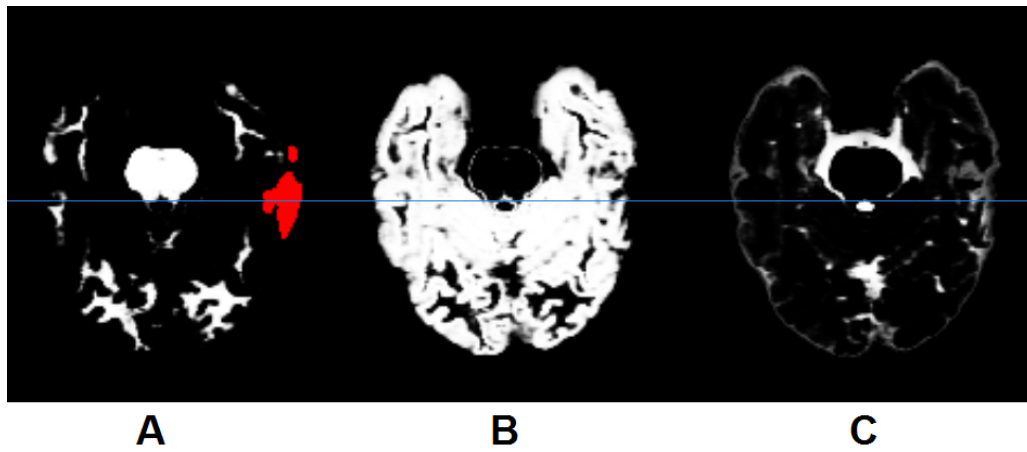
Most obvious slice of segmentations for patient P0836 MRI scan with emphasis on lesion area: grey matter TPM with manually delimited lesion area overlaid (A), white matter (B), CSF (C)
